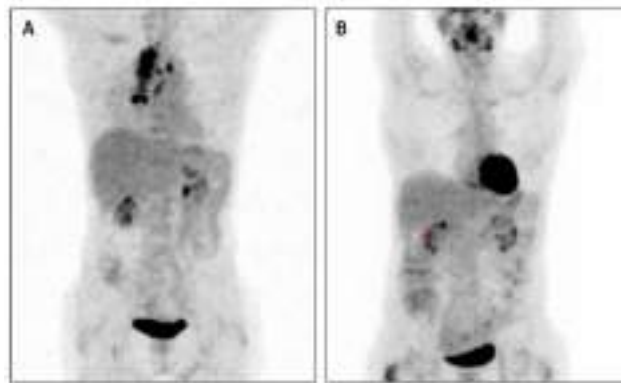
(A) The patient's PET-CT demonstrates right upper lobe mass with multiple mediastinal nodes (02/2017). (B) The Patient's PET-CT post crizotinib treatment present complete response (08/2018).
